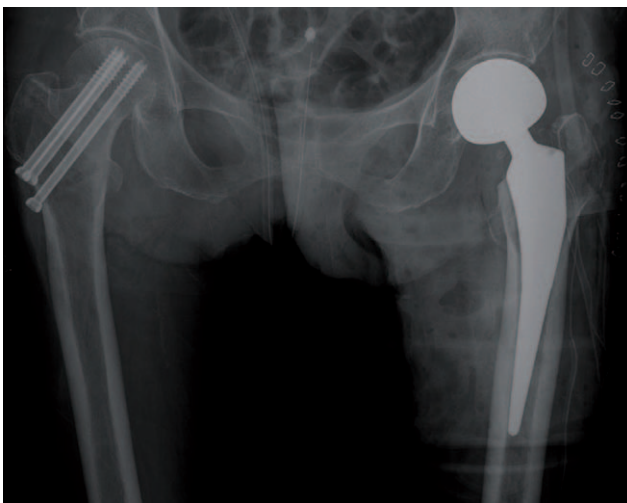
Anteroposterior radiograph of the pelvis shows bilateral femoral neck fractures treated surgically (*in situ* screw fixation of the right hip and bipolar hemiarthroplasty of the left hip).
